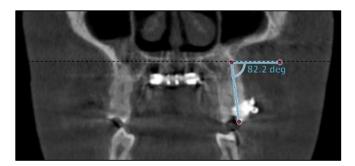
"A°L" parameter: CBCT image in the coronal plane.
